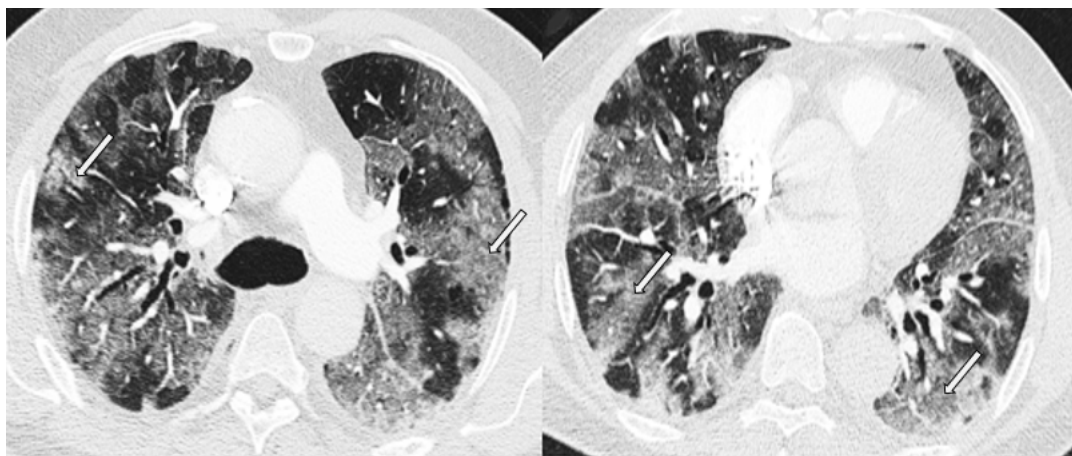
CT scan reveals worsening of the pulmonary bilateral ground-glass opacities, now associated with superimposed interlobular septal thickening and intralobular lines.
